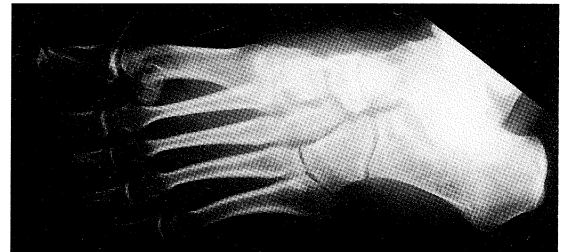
Plain radiograph of left foot showing marked periarticular osteoporosis at the metatarsophalangeal and interphalangeal joints.
